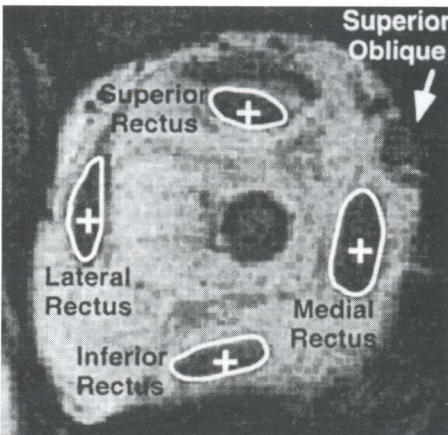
Three mm thick, 390  $\mu\text{m}$  resolution coronal MRI scan of the right orbit of a 26 year old woman with right hypertropia that increased in right gaze. Note 1.8 mm inferior displacement of MR and 1.7 mm nasal displacement of SR muscles. There was also a 2.3 mm superior displacement of the left LR muscle (not shown). The rectus cross sections have been digitally outlined and their area centroids marked with crosses.
